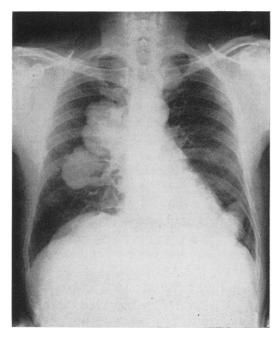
(Case 12) P. A. chest roentgen ray with bilateral pulmonary metastases.
